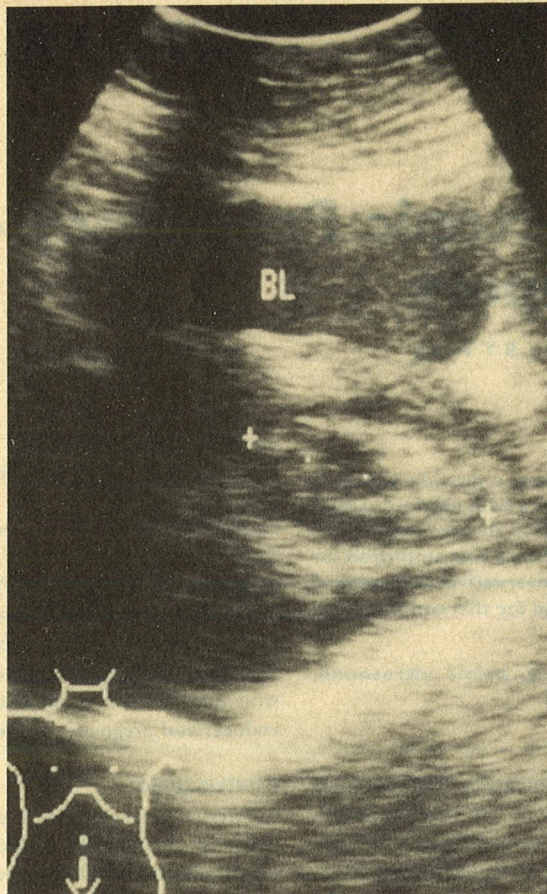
Ultrasonic picture of the cervical pregnancy
